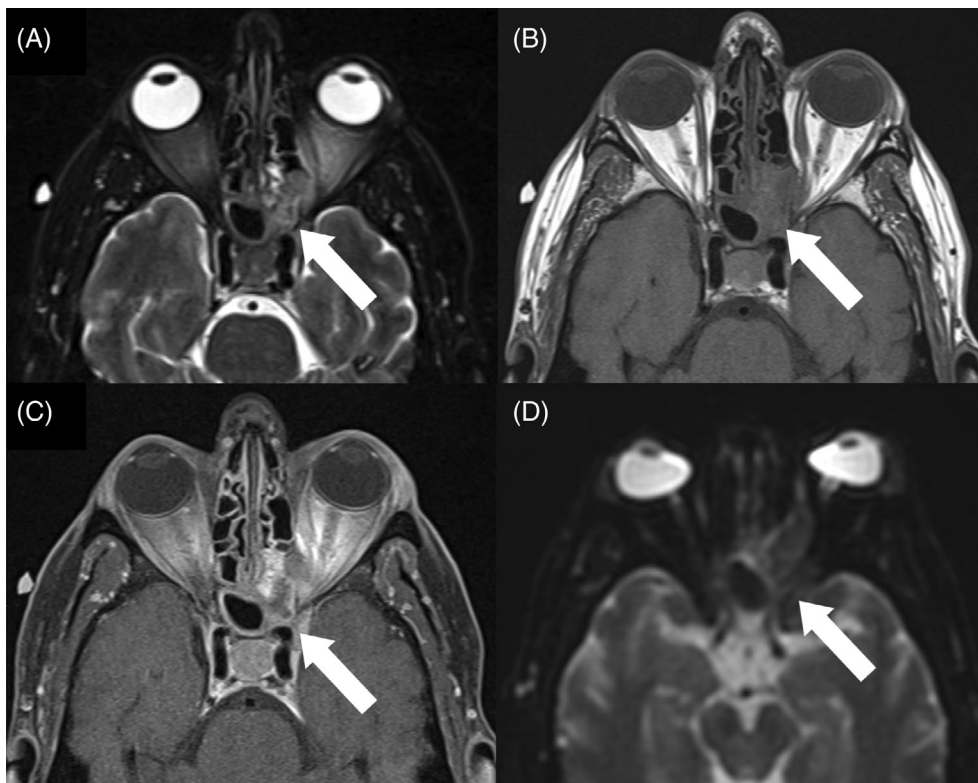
A 64-year-old male presenting with vision loss and ophthalmoplegia, found to have SN-DLBCL involving the left orbital apex. (A) Axial T1-weighted, (B) axial T2-weighted, and (C) axial T1-weighted post-contrast images demonstrating a left posterior ethmoid and sphenoid sinus mass extending into the left orbital apex (white arrow) resulting in vision loss. (D) Axial MRI diffusion-weighted imaging showing low signal
